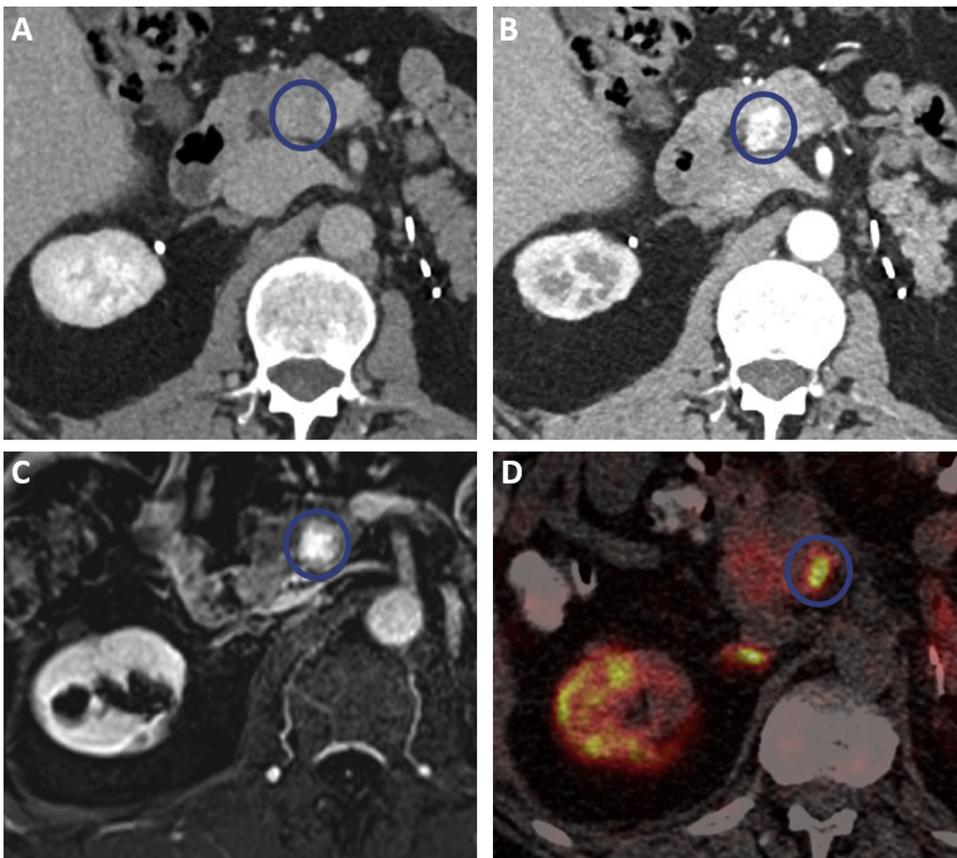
Typical appearances of pancreatic neuroendocrine tumors in patients with VHL in various imaging modalities: non-contrast computerized tomography (CT, A), arterial phase of contrast enhanced CT (B), magnetic resonance imaging T2 phase after injection of gadolinium (C) and ^{68}Ga -DOTATATE PET/CT fusion image (D).
